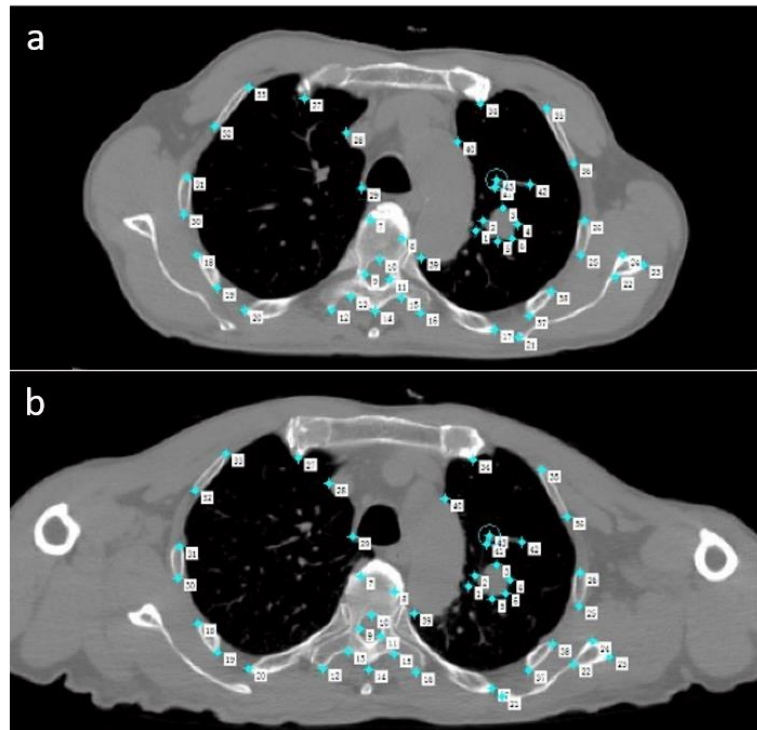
Registration of CT images before (a) and 48 hours after (b) CK radiotherapy with detail features as indicated by cyan stars.
